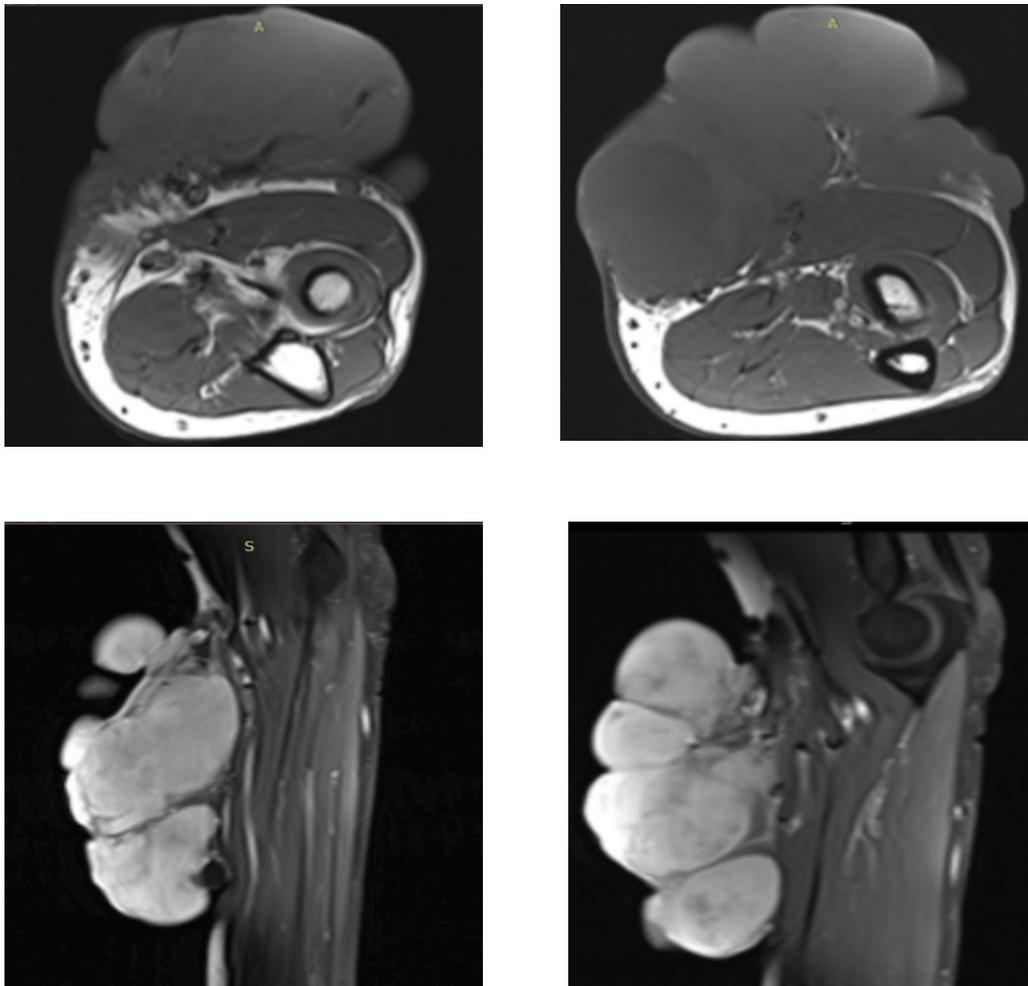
MRI findings show soft tissue sarcoma mainly located within subcutaneous region with no evidence of muscle infiltration or intraarticular extension
